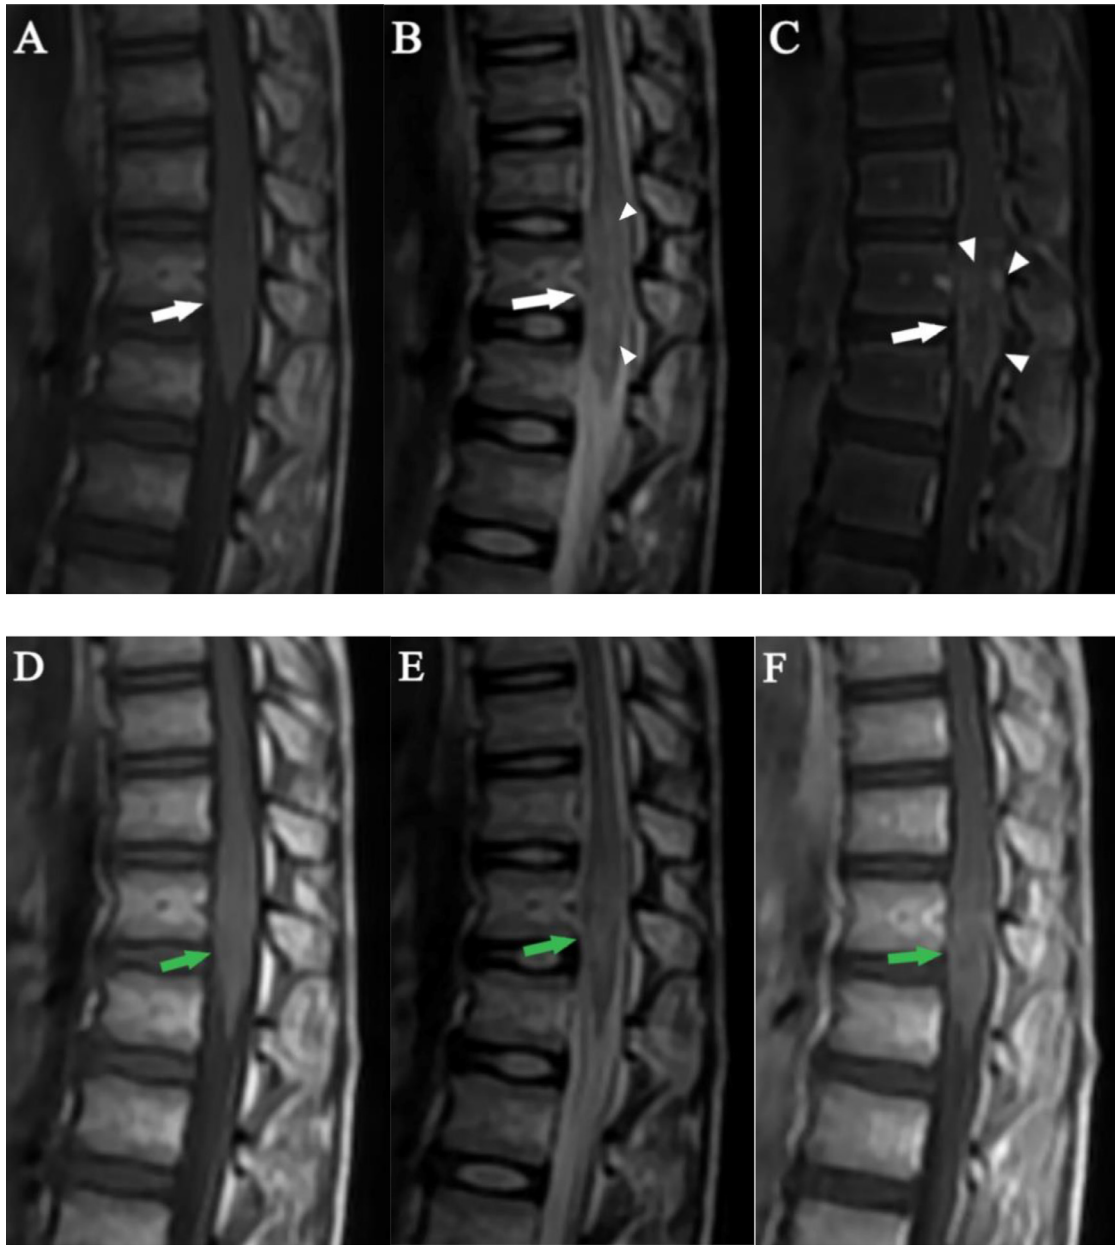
Pretreatment sagittal T1W (A), T2W (B), and T1 C+ (C) lumbo-sacral MRI images show expansion of the conus (white arrows in A-C). On the T2W image, there was a central linear hyperintense signal (white arrowheads on B). Furthermore, peripheral nodular-linear pattern of enhancement was surrounding this central signal on the post contrast image (white arrowheads on C). On the 2 month post-treatment follow-up MRI in T1W (D), T2W (E), and T1 +C (F) sequences, there was a reduction in the level of the conus swelling and marked decrement in enhancement (green arrows in D-F). There was still some central and peripheral residual enhancement seen.
